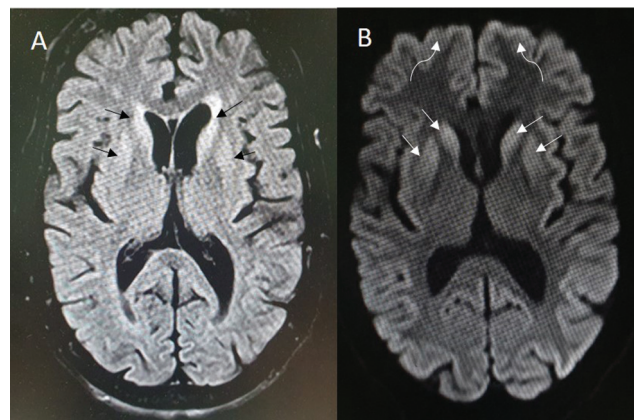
A 65-year-old woman presented with behavioral abnormality 1 day after receiving the second dose of ChAdOx1 vaccine, which rapidly deteriorated to incoherent speech, aggravated forgetfulness, hallucinations, abnormal movements of limbs, and jaw and neck dystonia. (A) Magnetic resonance imaging (MRI) axial fluid attenuated inversion recovery (FLAIR) and (B) diffusion weighted images showed FLAIR hyperintensity (black arrows) and diffusion restriction in bilateral caudate, putamina (white arrows), and the cerebral cortex in bilateral hemispheres (curved arrows). Electroencephalogram (EEG) revealed bilateral biphasic and triphasic sharp wave periodic discharges of 1 Hz, with slowing of background activity, suggestive of Creutzfeldt–Jakob disease. Over the next 2 weeks, she developed respiratory distress and shock and died after 1 month of admission.
